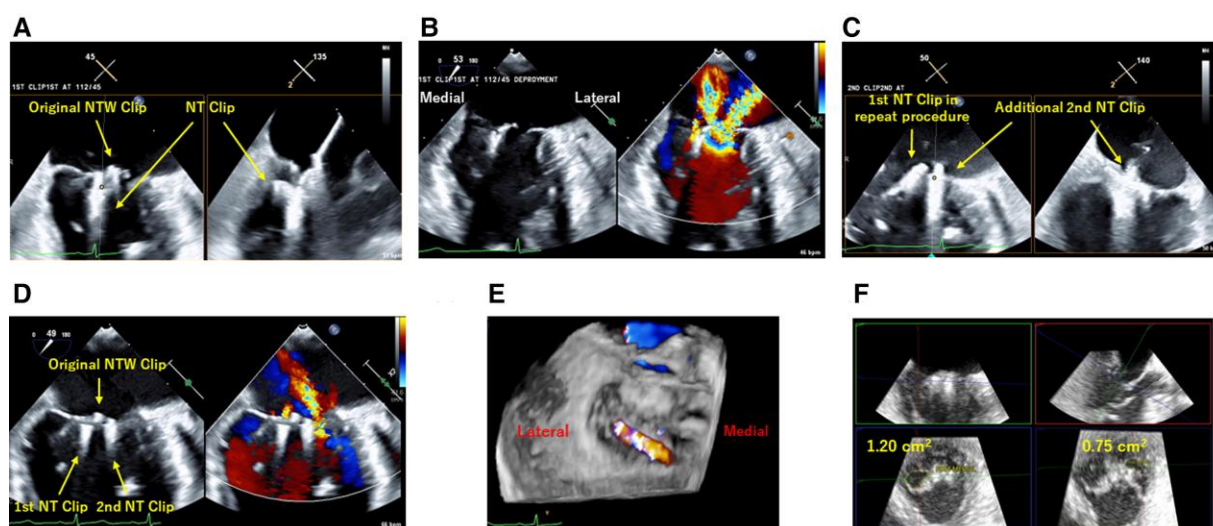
Transoesophageal echocardiography and fluoroscopy imaging during repeat clipping. (A) An NT clip is placed medial to the original NTW clip. (B) Mitral regurgitation on the medial side of the original NTW clip disappeared after the first clip deployment. (C) A second NT clip is placed lateral to the original NTW clip. (D) After placement of the second NT clip, mitral regurgitation is reduced to mild. (E) Improvement of mitral regurgitation is confirmed after placement of the second NT clip on three-dimensional colour imaging. (F) The mitral valve area calculated by three-dimensional multiplanar reconstruction is 1.95 cm².
